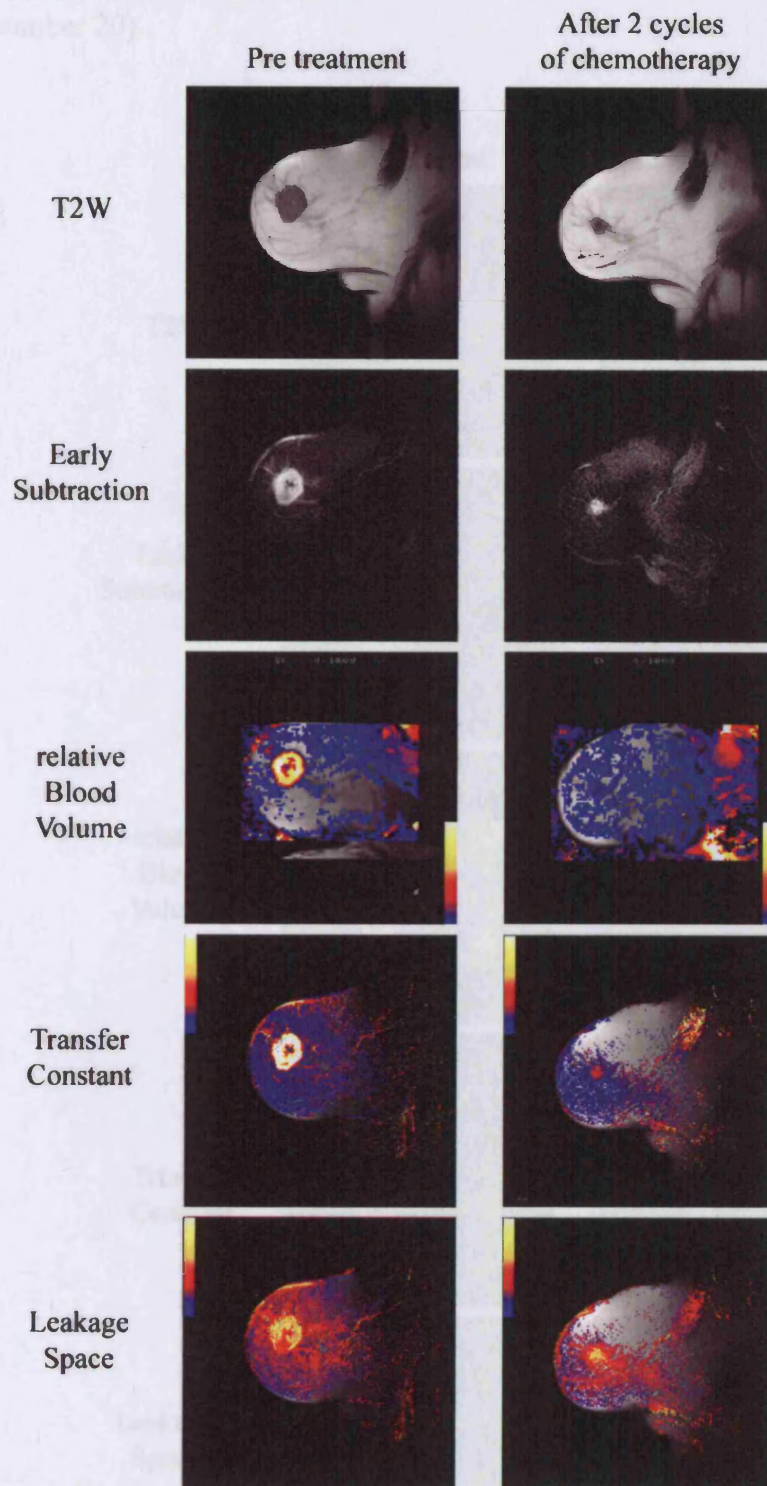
Pre-treatment and post-2 cycles of neoadjuvant FEC chemotherapy DCE-MRI images in a non-responding patient (patient number 20)
